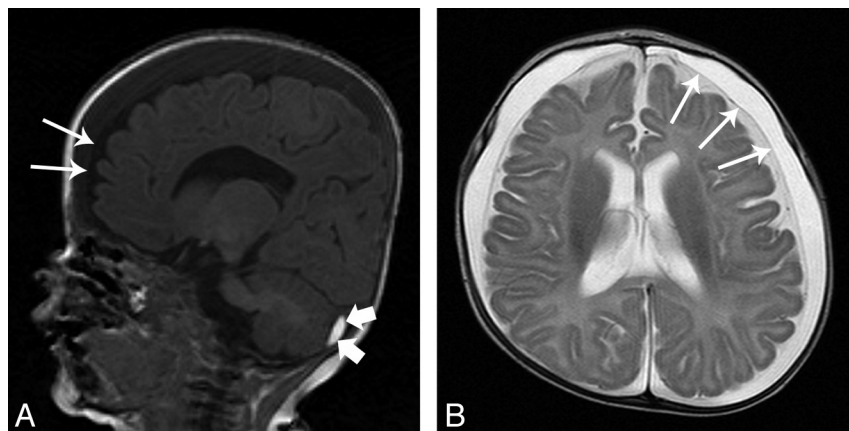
MR imaging scan of a 5-month-old female infant who showed a sudden increase of head circumference (from 50th to 97th percentile within 1 month). Frontoparietal SDHs (maximum width of 11 mm) as well as enlarged subarachnoid spaces (maximum width of 4 mm) were found on both sides (A, sagittal T1-weighted image; B, axial T2-weighted image; *thin arrows* indicate position of the subarachnoid membrane). In addition, a small subacute SDH was diagnosed in the left posterior cranial fossa beneath the tentorium cerebelli (A, *small thick arrows* indicate subdural blood). In the preceding months, periodic sonography scans of the head did not ever show any abnormalities with respect to the subdural or subarachnoid space. Ophthalmologic examination revealed sub- and epiretinal hemorrhages distributed over the whole fundus area of both eyes. These retinal hemorrhages were not present yet in a check-up examination 1 month after birth. As further clinical diagnostics have ruled out coagulopathies, neoplastic diseases, and metabolic disorders, the presence of SDH and retinal hemorrhage prove substantial (sub)acute head trauma and therefore strongly suggest child abuse (AHT). The enlarged subarachnoid spaces, found after the trauma diagnosis, have rather to be regarded as consequence and not as source (see “BESS” section). Hence, the SDHy in this well-documented case can be regarded as a result of acute injury.
